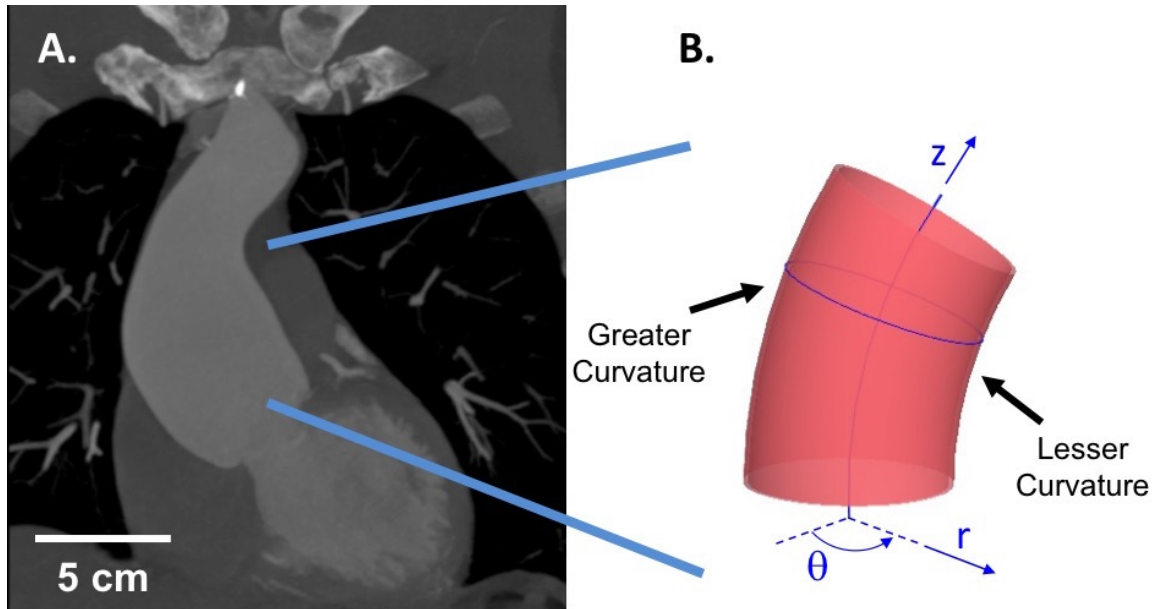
A) A coronal view of a patient ATAA from a CT scan. Scale bar shown in white. B) Conventions used for circumferential ( $\theta$ ), axial ( $z$ ), and radial ( $r$ ) directions. Greater and lesser curvatures also indicated.
